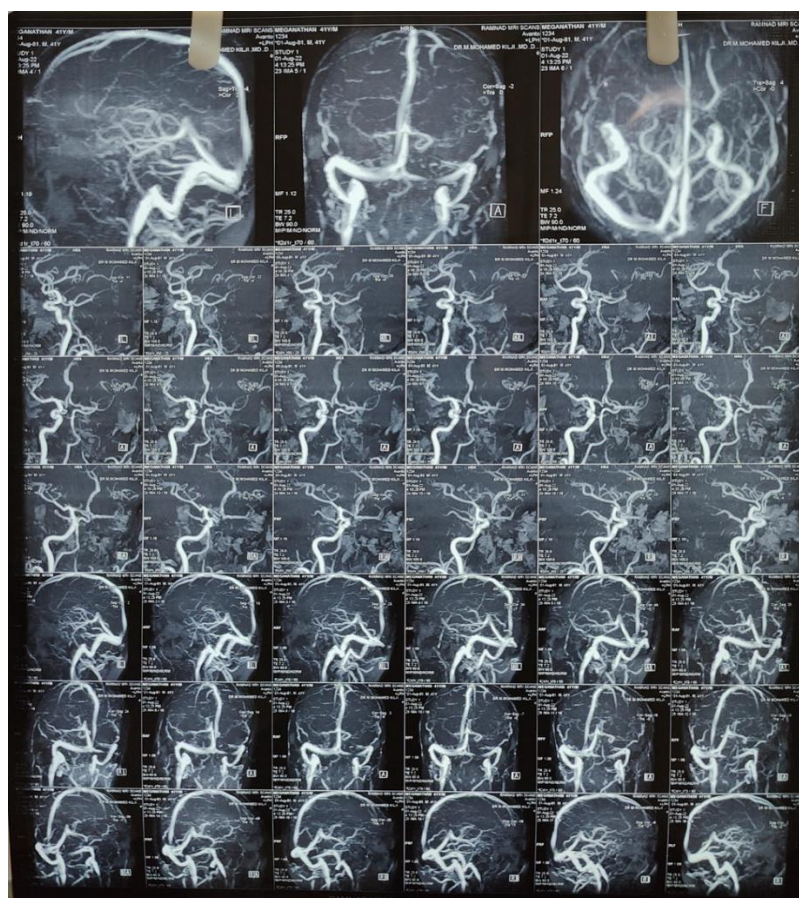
MRI Brain With MRA
